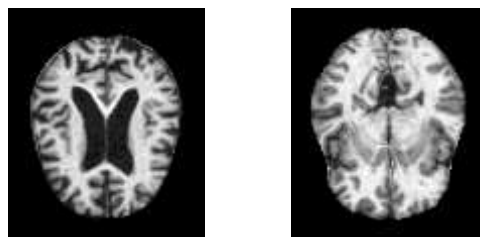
Shows AD and normal (NC) brain MR images.
